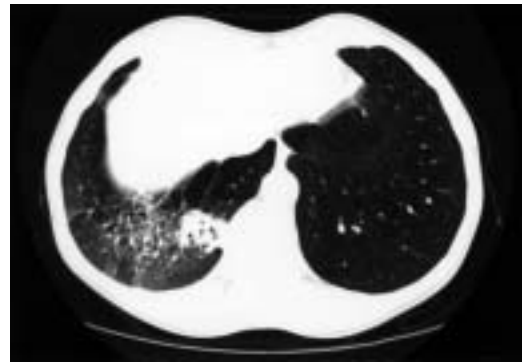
Computed tomogram showing coccidioidal consolidation in right lower lobe.
